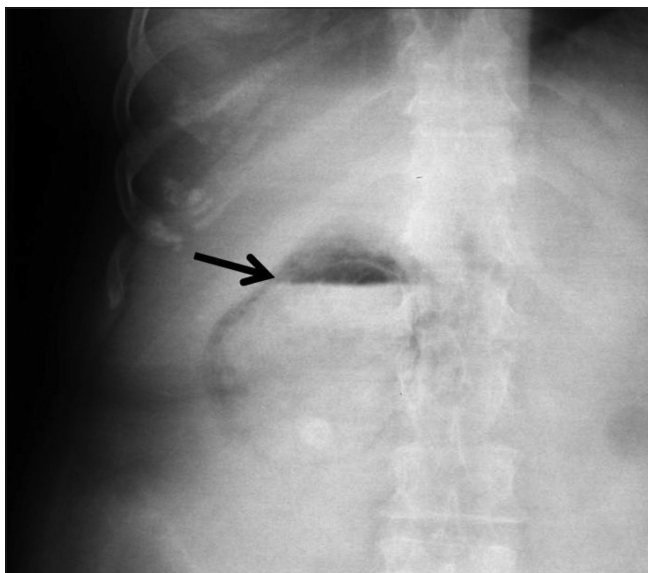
Abdominal radiograph (frontal projection) shows intraluminal air (arrow) with air–fluid levels
